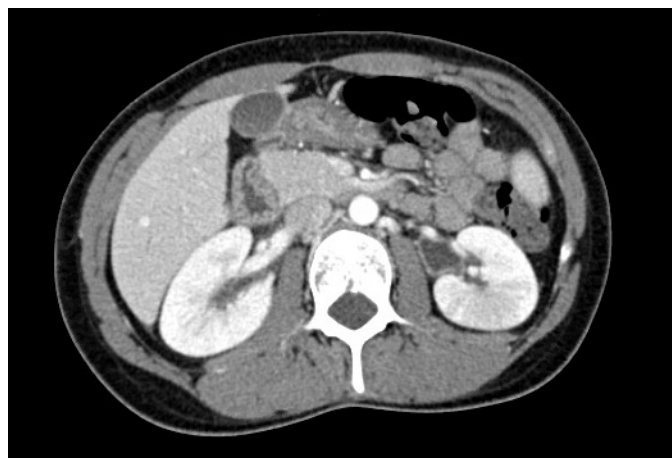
CT scan of the abdomen and pelvis with contrast demonstrated areas of hypoattenuation of the kidneys, greater on the left side. Subsequent images showed bilateral ureteritis extending to the level of the bladder.
